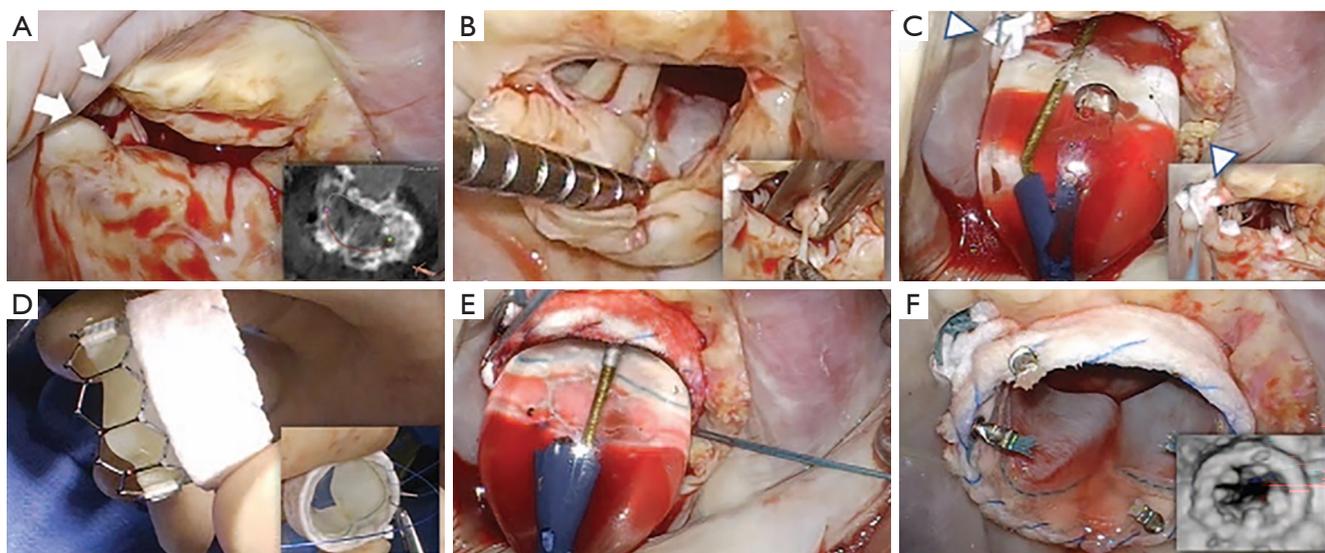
A case of hybrid transatrial TMVR. Hybrid TMVR in severe MAC. (A) Intraoperative surgeon's view of the calcified mitral valve—anterolateral commissure (white arrows) spared of severe MAC (PIP: computed tomography reconstruction of circumferential MAC); (B) partial resection of the anterior mitral leaflet from commissure to commissure with debulking of hypertrophic papillary muscle tips to increase intracavitary space (PIP); (C) plication of the anterolateral commissure (arrowheads) to circularize the orifice and initial prosthesis sizing following complete anterior leaflet flip (PIP); (D) a Teflon-felt cuff is fashioned and secured around the outer sealing skirt of the S3 prosthesis (see text for details); (E,F) the S3 is inflated under direct vision and secured *in situ* (PIP: 3D-Doppler reconstruction of the S3 in mid-systole showing no paravalvular leak). Reproduced with permission from El-Eshmawi *et al.* © 2020 Wolters Kluwer Health, Inc. MAC, mitral annular calcification; PIP, picture-in-picture; S3, SAPIEN 3; TMVR, transcatheter mitral valve replacement.
